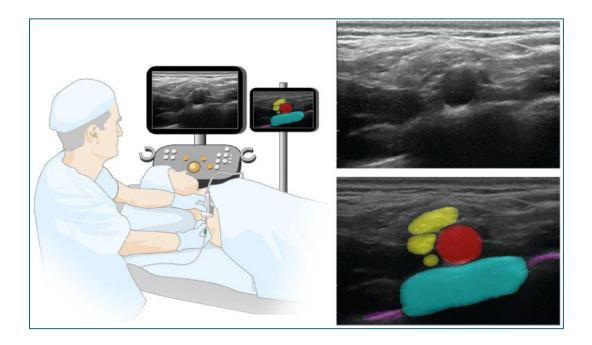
ScanNav (Intelligent Ultrasound, UK) system. A second slave monitor overlays the AI prediction over the ultrasound image.
